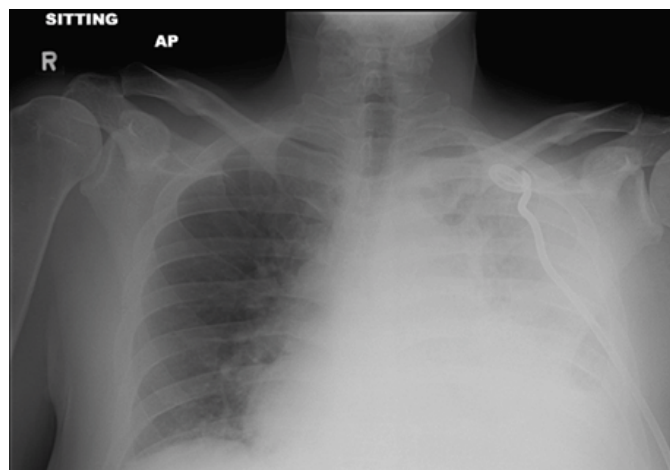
Chest X-ray showing increased opacification of left hemithorax post-thoracostomy on day three: Mild cardiomegaly. Two pigtail chest tubes overlie the hemithorax, one at the apex, and one inferiorly at the lateral costophrenic sulcus. There is opacification of the intervening left hemithorax, which may be on the basis of infiltrate or pleural fluid. The right lung is clear. There is no pneumothorax on either side.
